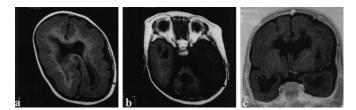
Brain MRI of patient at age 3 years shows agyric frontal and temporo-occipital lobes mixed with pachygyric parietal cortex, hypoplasia of brain stem and cerebellum, and defect of septum pellucidum. The periventricular white matter change (A and B, TR540/TE15; C, TR5400/TE90) also is seen.
